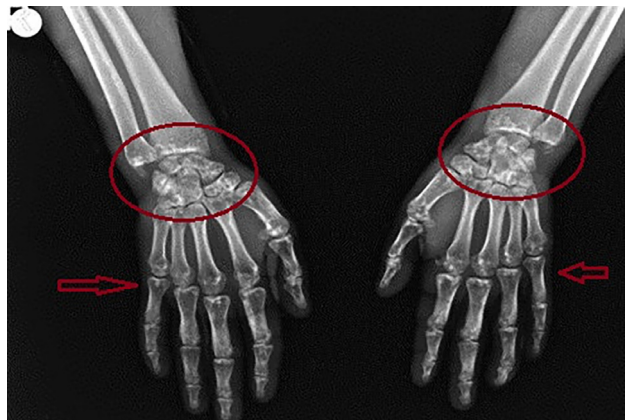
Radiograph of the left hand and wrist revealing sclerotic lesions in the carpal bones, metacarpals, and phalanges. A positive distal radioulnar joint test was noted on the left side
